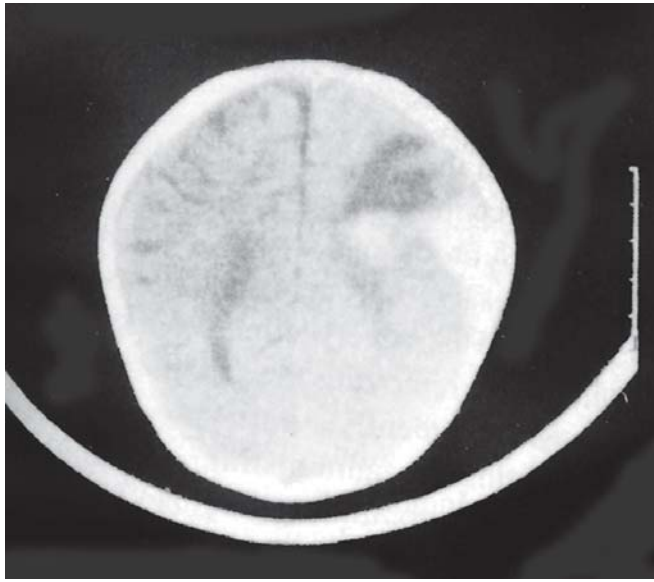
CT scan showing intracerebral hemorrhage in a child with left-sided hemiplegia
